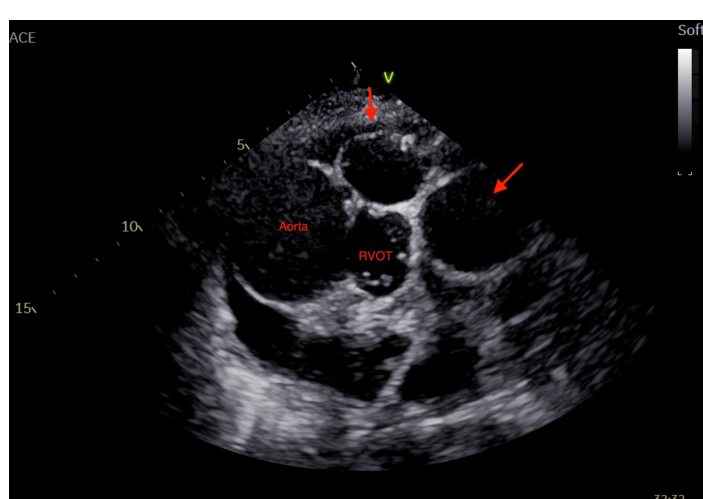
2 giant coronary aneurysms located next to the RVOT in parasternal short axis view (PSAX)
